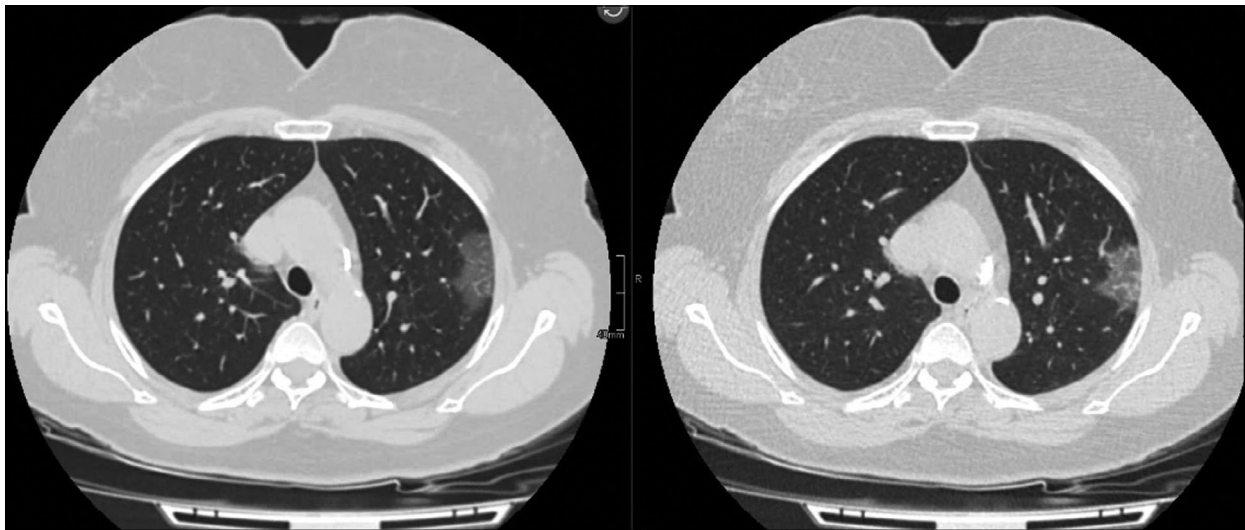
Radiation exposure is reduced by 5 times. Patient, 59 y. o., BMI 29 kg/m². Computed tomography with a soft tissue filter (effective dose: 9.7 mSv), low-dose computed tomography with a soft tissue filter (effective dose: 2.1 mSv). In the upper lobe of the left lung, there was a peripheral ground-glass lesion.
